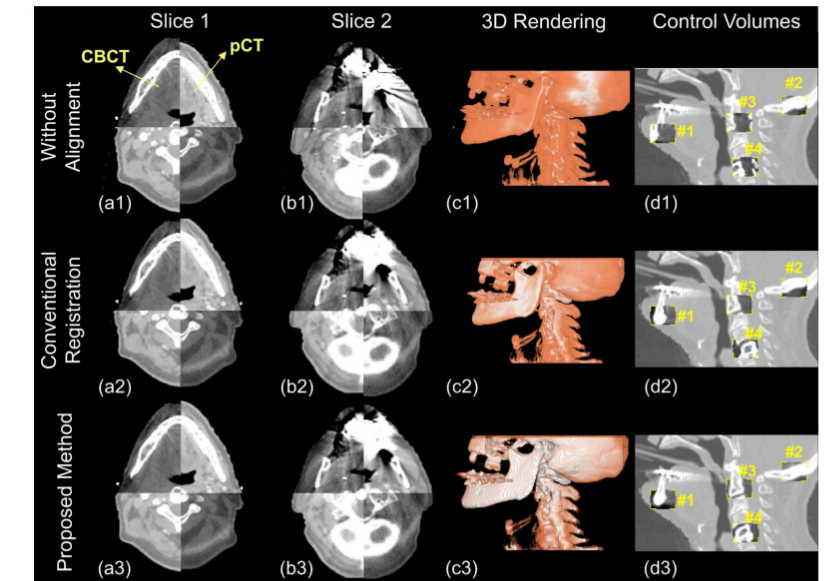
Examples of CV mapping results on the CBCT image of an HNC patient. Rows (1), (2) and (3) show results without alignment, with conventional global alignment, and with the proposed method, respectively. Columns (a) and (b) show checkerboard displays of two axial slices. Column (c) shows superposition of 3D renderings (image differences are highlighted in orange). Column (d) shows the selected yellow rectangular CVs, #1 to #4, as overlays on the background pCT image, with the image in each corresponding to a volume of interest cropped from the transformed CBCT image.
